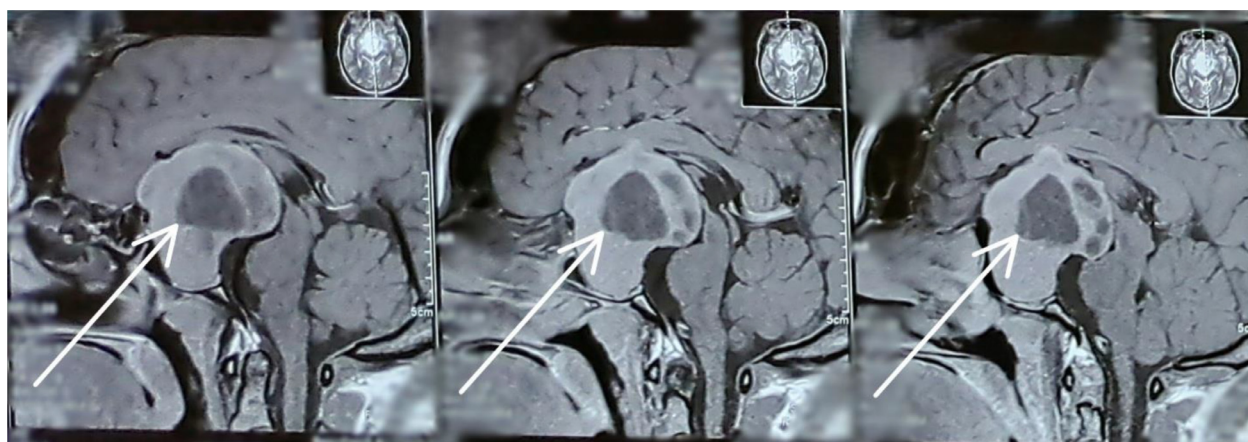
Sagittal T1-weighted postcontrast MRI depicting a large, homogeneously enhancing pituitary macroadenoma within the sella turcica, expanding into the suprasellar region with well-defined borders (marked by arrows).
